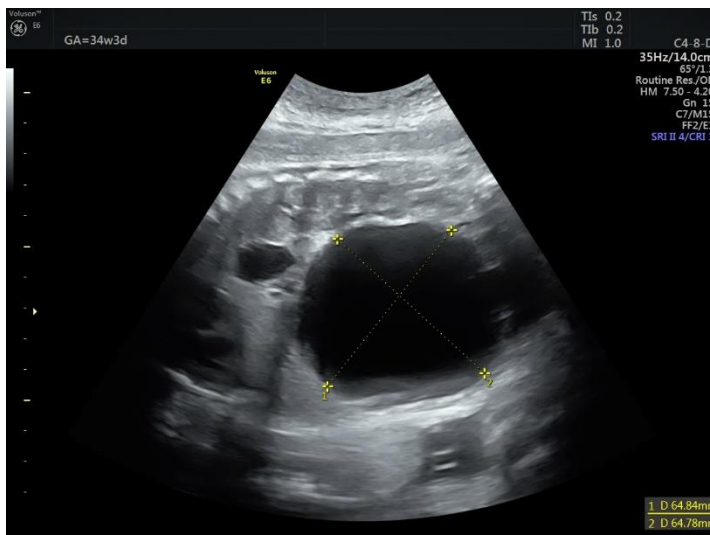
Sonogram of a simple fetal ovarian cyst.
